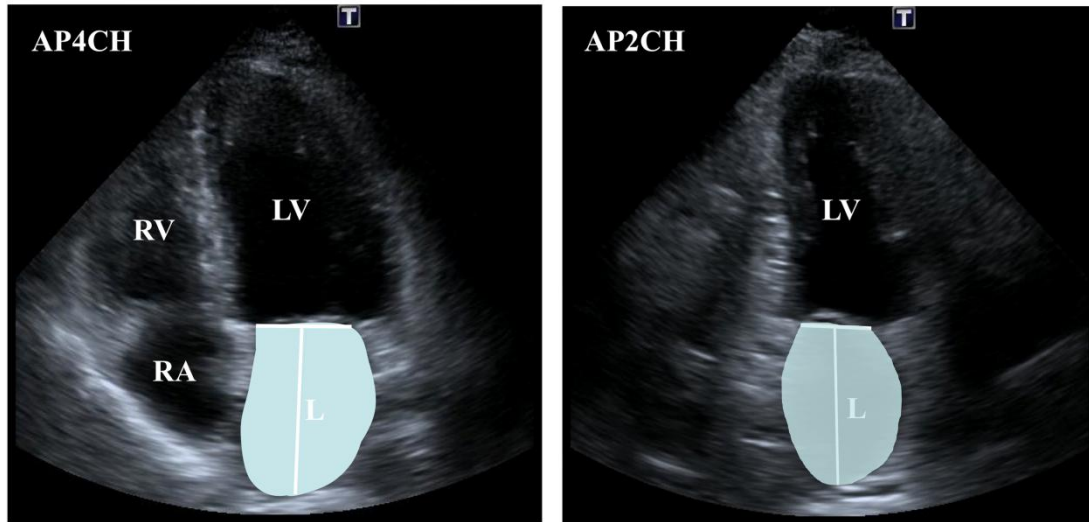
Calculation of left atrial (LA) volume using 2-dimensional echocardiography by manual tracing of LA endocardial border at apical 4-chamber (AP4CH) and 2-chamber views (AP2CH). L is the long axis, then apply the formula.
